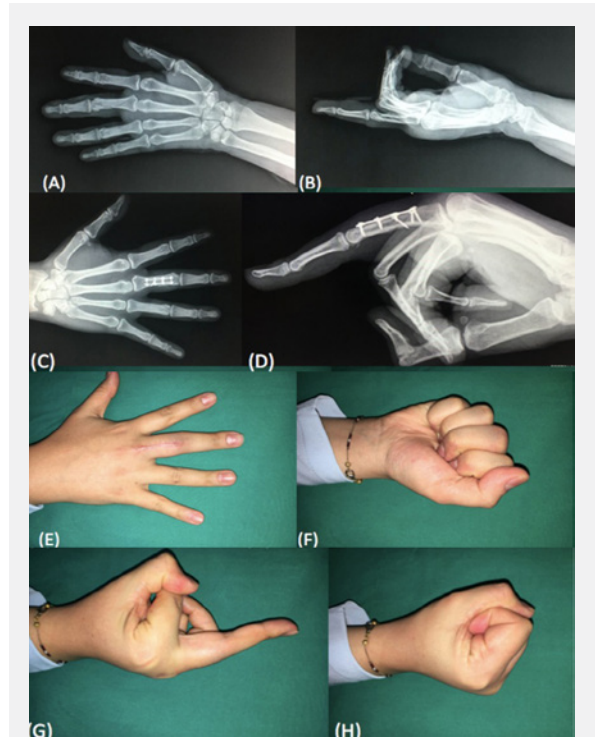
A-H. Plain anteroposterior radiograph of the 3rd proximal phalanx shaft, spiral fragmented fracture due to a fall on the left hand (A), lateral radiograph (B), postoperative 6th month anteroposterior direct radiograph (C), plain lateral radiograph (D), images demonstrating functional joint movements; dorsal incision scar, extension of the finger and the hand (E), volar fist position (F), isolated 3rd finger extension (G) and image of the lateral fist position of the hand (H).
